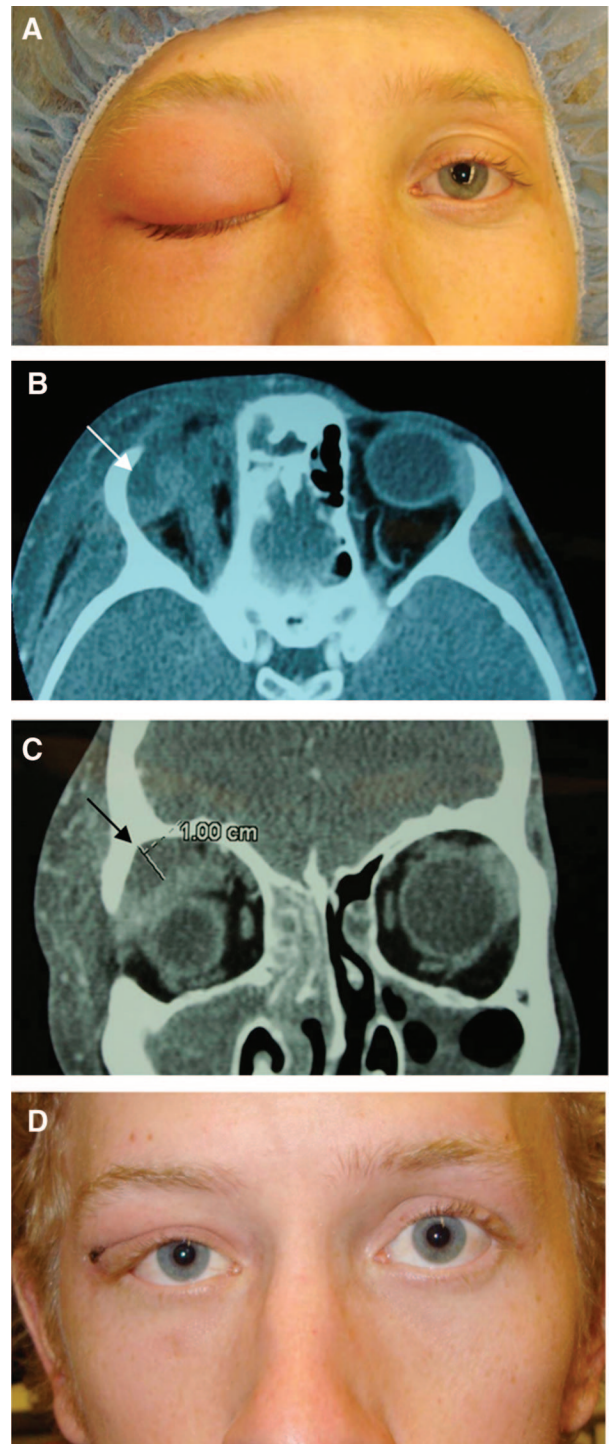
Case 2. (A) A 20-year-old man on presentation with right orbital cellulitis. (B) Axial and (C) coronal CT of the right superolateral extraconal orbital abscess (arrows); 10 mm in greatest dimensions. (D), Two weeks after drainage of orbital abscess with marked resolution of orbital cellulitis.
